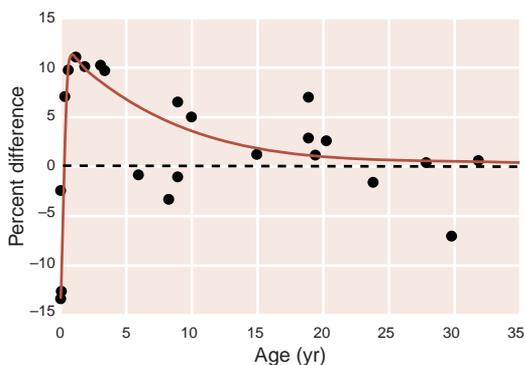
• A meta-analysis of brain measurements including head circumference and magnetic resonance imaging scans are plotted by percent difference from norm and age. (Adapted from Redcay E, Courchesne E. When is the brain enlarged in autism? A meta-analysis of all brain size reports. *Biol Psychiatry*. 2005;58(1):1-9.)
